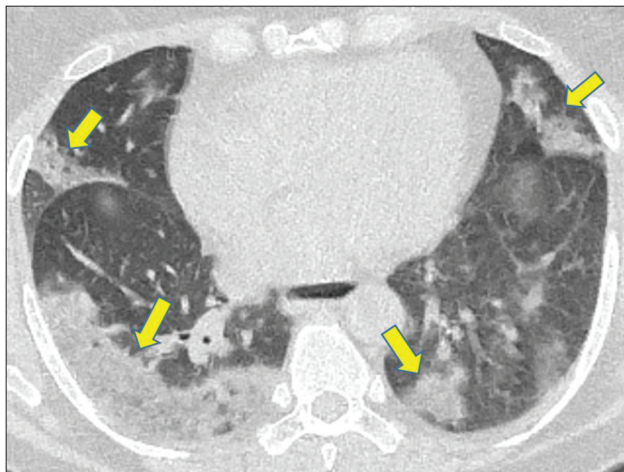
A 55-year-old female coronavirus disease 2019 patient. A computed tomography scan revealed bilateral multifocal consolidations (yellow arrows)
